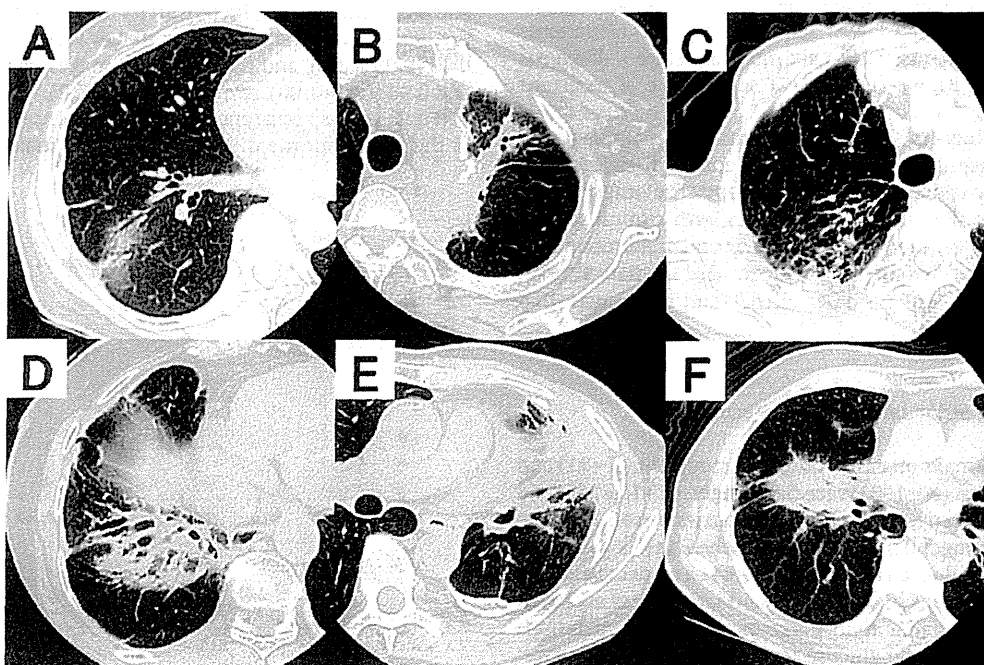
Typical CT images of radiation-induced lung opacities. (A) Ground glass opacity (GGO), (B) scar, (C) fibrous change, (D) consolidation with air-bronchogram (AB), (E) consolidation only, (F) nodular opacity. All representative radiation-induced lung opacities were not associated with recurrence.
